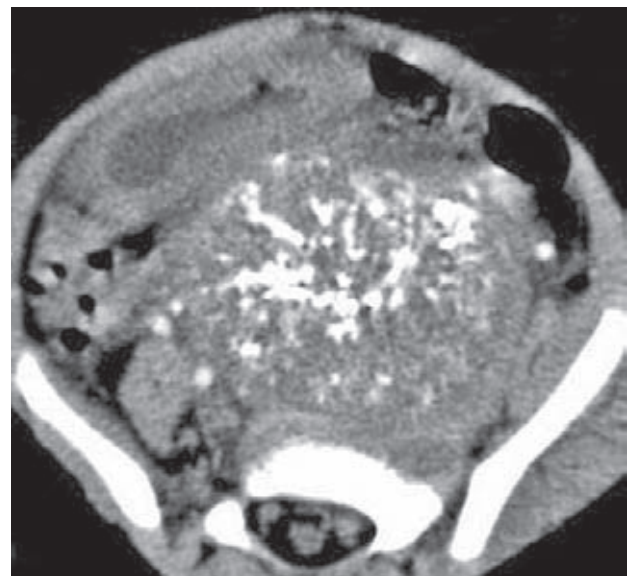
Neuroblastoma: CT scan showing a calcified lower abdominal mass with presacral lymphadenopathy
